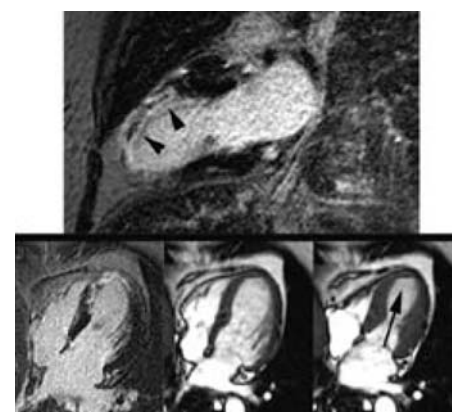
DE-MRI in acute myocardial infarction. The lower images demonstrate DE-MRI (left) and cine images in end-diastole (middle) and end-systole (right). DE-MRI reveals transmural irreversible damage of the distal septum and apex, while the cine images reveal corresponding dysfunctional myocardium (arrow). The DE-MRI image in the upper row was performed in the two-chamber long axis projection and reveals transmural hyperenhancement of acute irreversible damage in the LAD distribution. Note the microvascular obstruction (‘no-reflow’ or focal non-hyperenhancing regions) in the subendocardium of the anterior wall (arrowheads) that is associated with greater post-infarction complications and poorer prognosis.
